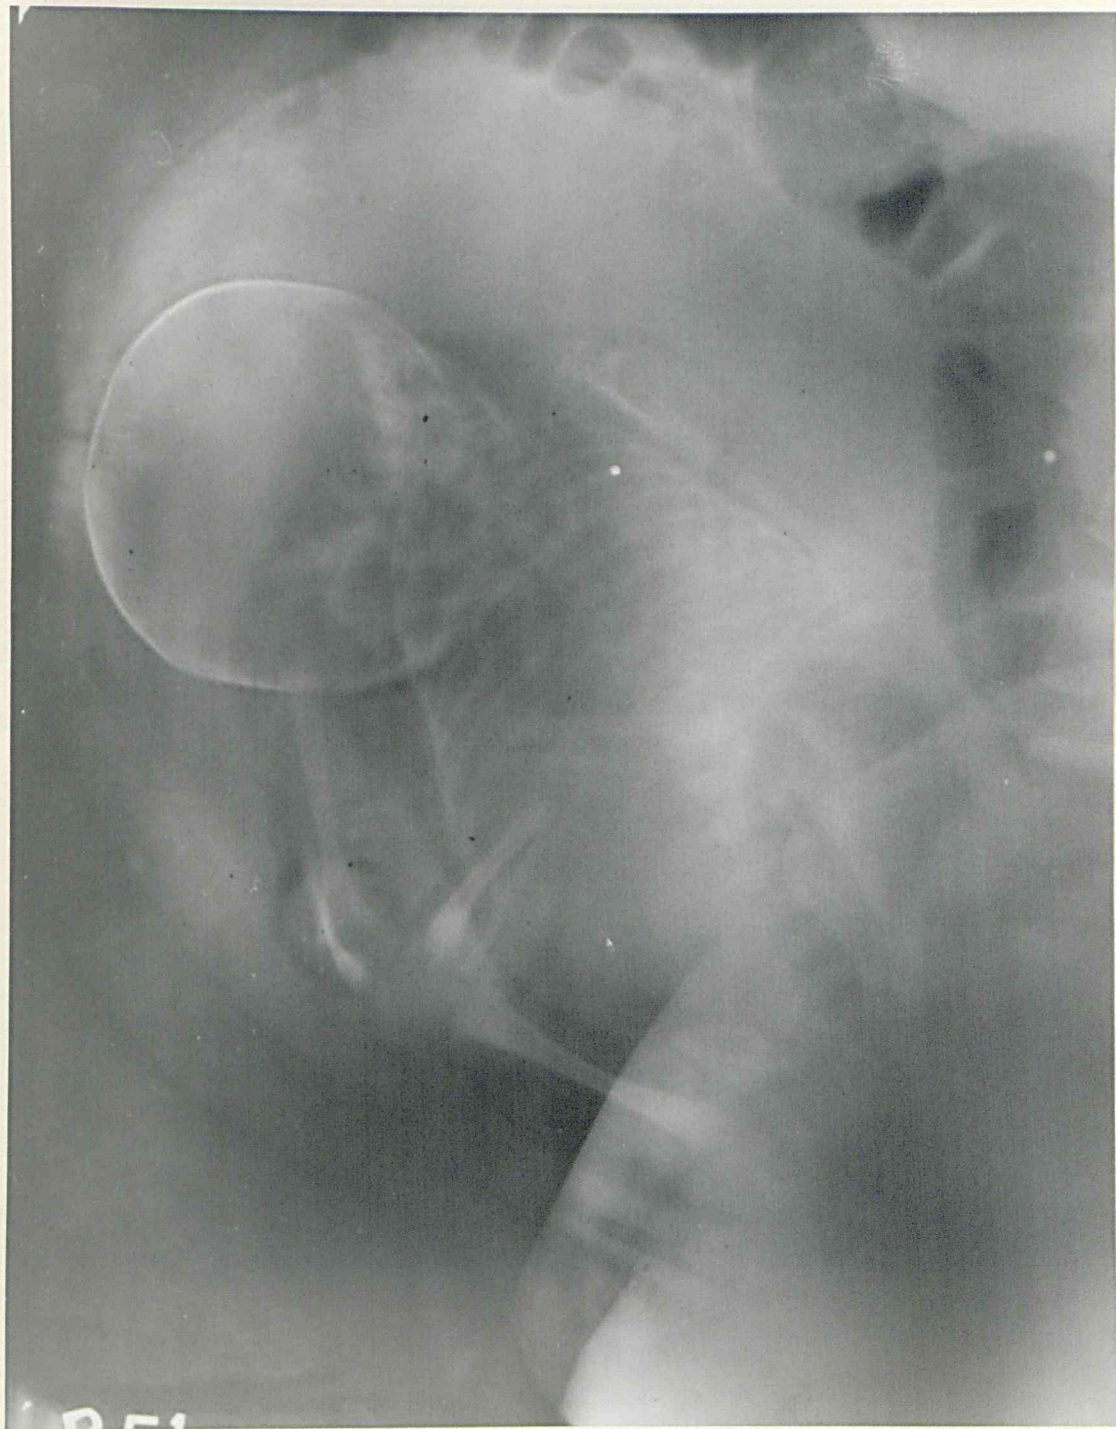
Lateral radiograph of the abdomen in a breech presentation. Fundal cornual appearance due to implantation of the placenta over a cornu of the uterus. (Case No. 35).
